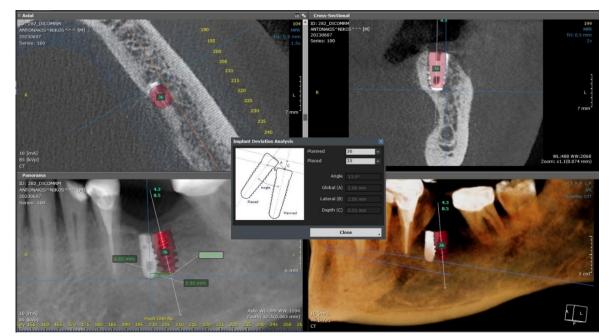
Superimposed CBCT images of virtual implant and inserted implant for measurement of linear and angular deviations.
